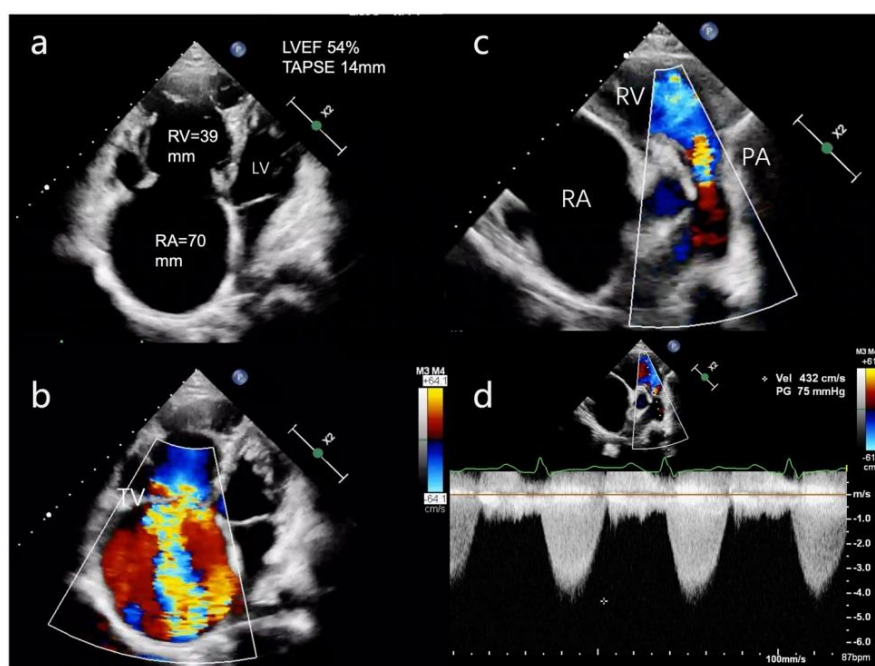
Transthoracic echocardiography of the isolated absent pulmonary valve syndrome patient.
